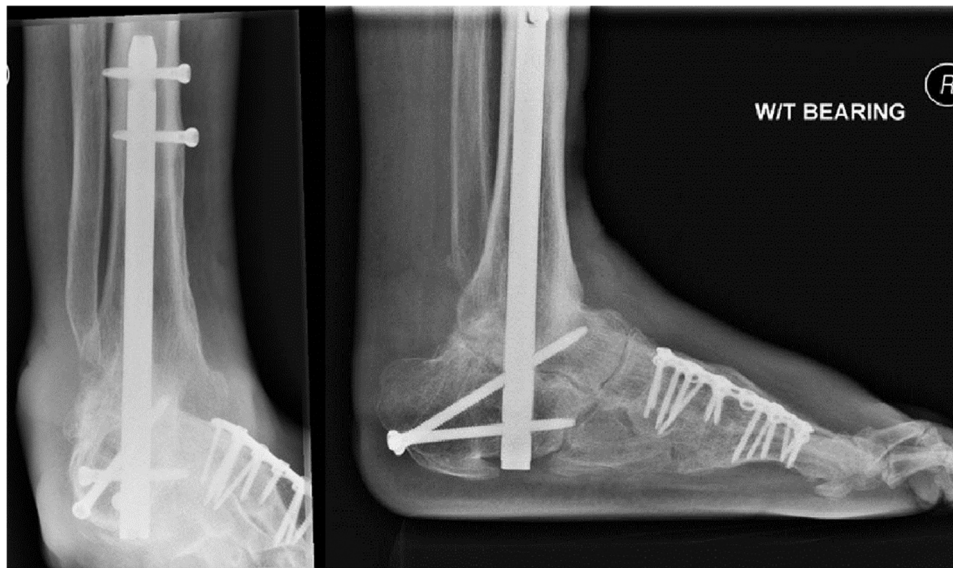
Post-operative X-rays for case 2.
